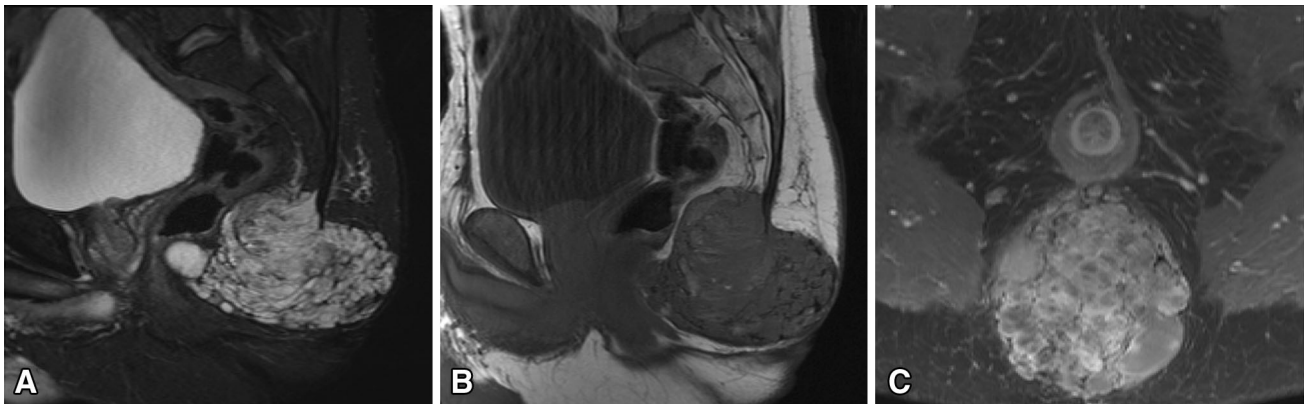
Surgically proven sacral chordoma. A Sagittal fat-saturated T2-weighted image shows a hyperintense mass centered midline in the distal sacrum. B Sagittal T1-weighted image shows a predominantly hypointense mass with several hyperintense foci, suggesting hemorrhagic or mucinous
